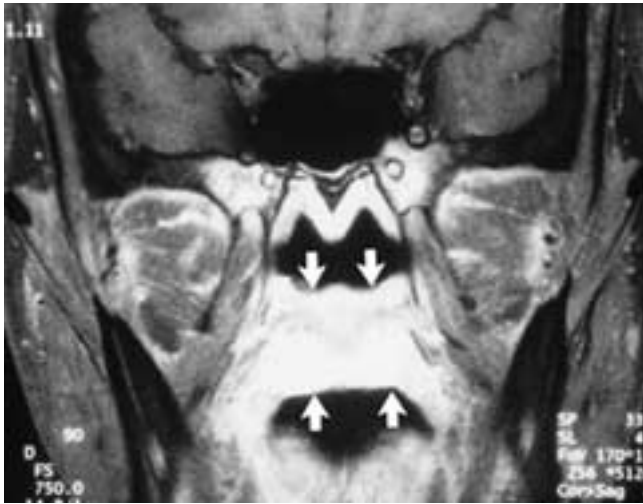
Coronal postcontrast T1-weighted image performed following fat saturation shows diffuse enlargement and enhancement of the soft palate (*arrows*) due to an infiltrating carcinoma.
